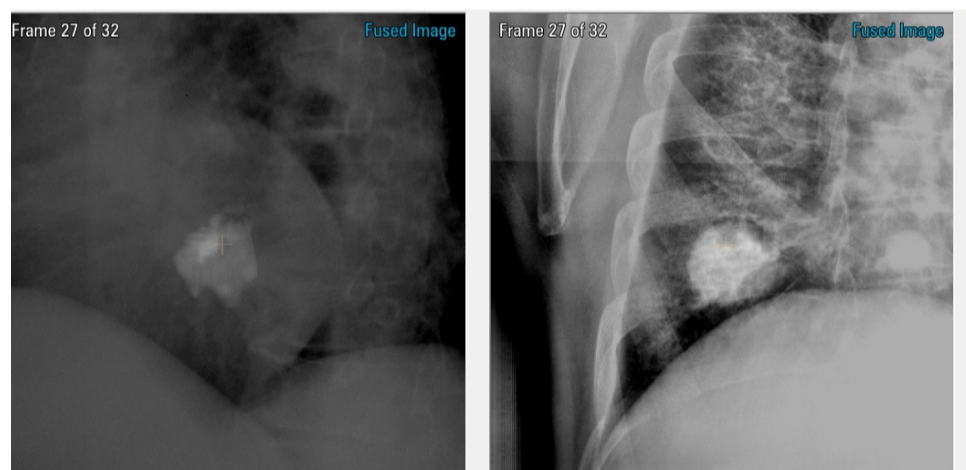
Fusion of the CT and DRR shown for one frame out of all the analyzed fluoro-sequences.
